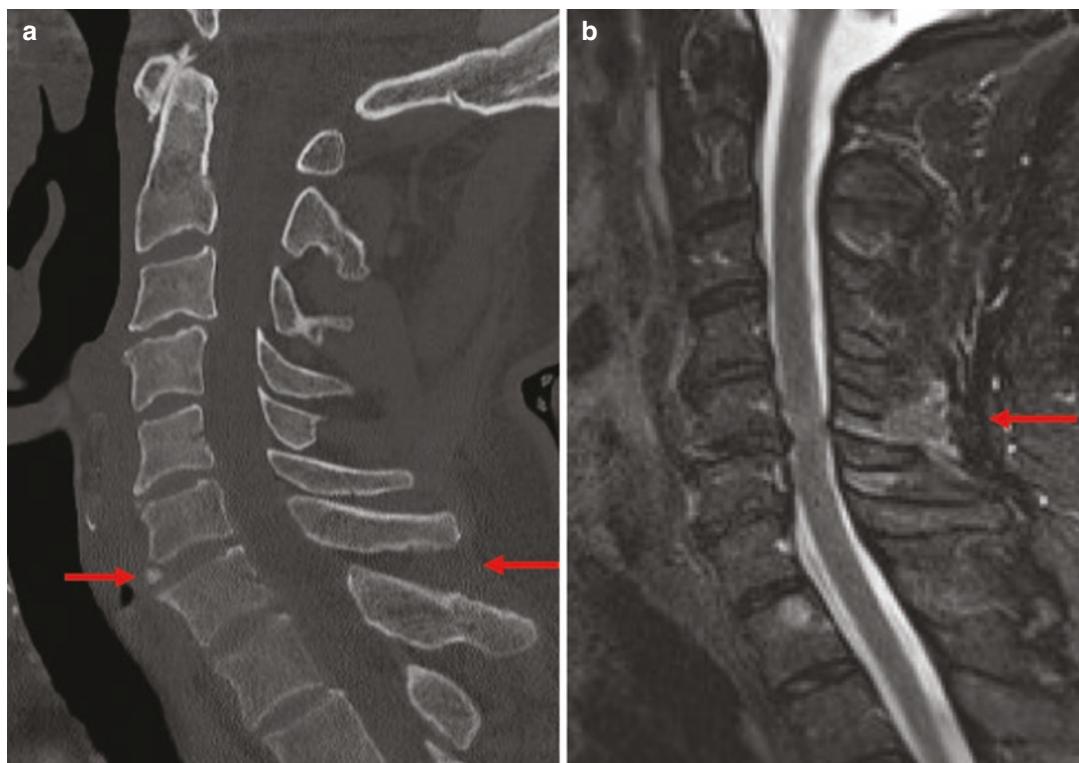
Flexion-teardrop fracture in a 37-year-old woman involved in a motor vehicle collision. (a) Sagittal cervical spine CT reformation shows a teardrop fracture at the anterior-inferior aspect of the C6 vertebral body (red
